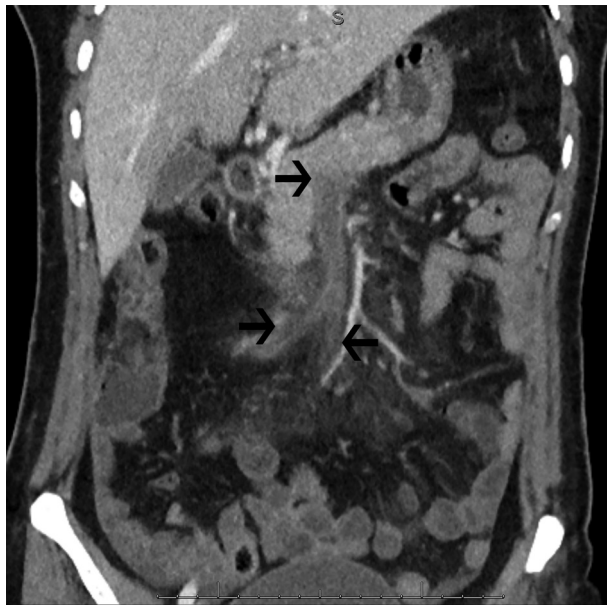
CTA image of SMA thrombosis.
